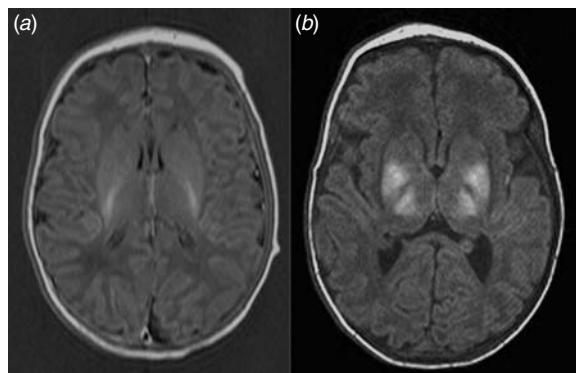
(a) T1-weighted magnetic resonance image from a normal newborn infant, showing characteristic high signal in the posterior limb of the internal capsule, and (b) image of an infant with severe perinatal hypoxic–ischemic injury showing high signal in the basal ganglia and thalamus, and loss of signal in the posterior limb of the internal capsule.
